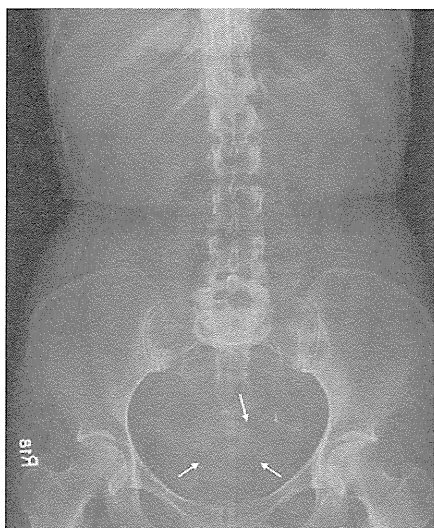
Plain abdominal radiograph showed the T-shaped intrauterine contraceptive device (IUCD) in the left pelvic cavity. The surrounding fat planes of the uterus were identified (arrows) and the device appeared separate from the fat planes.
